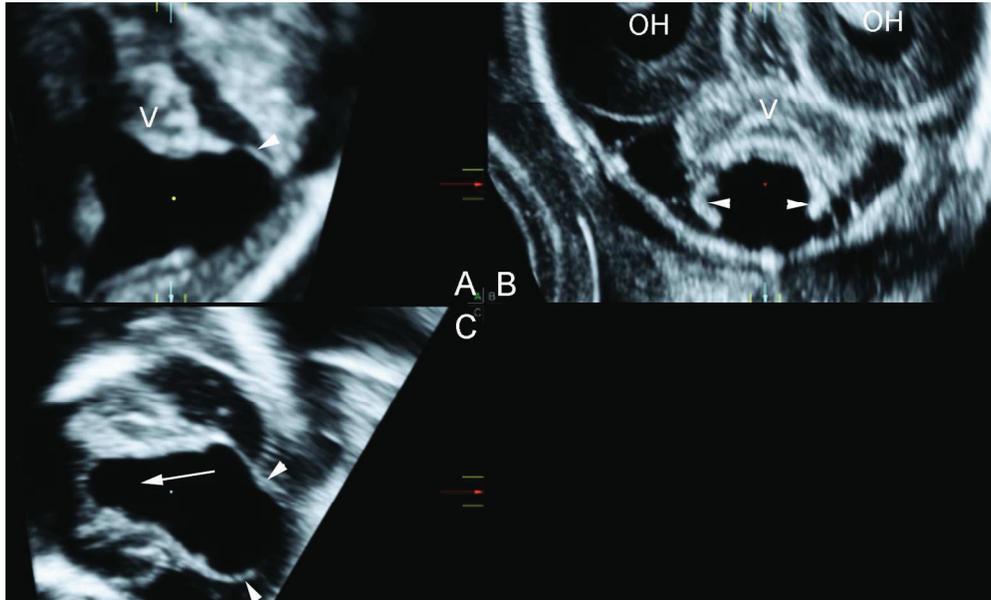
Blake's Pouch Cyst at 22 weeks of gestation. Three-dimensional ultrasound with multiplanar and volume contrast imaging. A) on the midsagittal view, the anti-clockwise rotation of the normal vermis (V) and the roof of the Blake's pouch cyst (arrowhead) are evident; B) on the corresponding coronal view, two tufts of choroid plexus (arrowhead) can be seen on the supero-lateral margins of the cyst wall, just below the vermis (V); C) on the axial plane, the classic "keyhole sign" (arrow) is seen, with non-visualization of the vermis in between the two cerebellar hemispheres. This sign leads to referral for expert opinion and final diagnosis. The lateral walls of the cyst are evident (arrowheads).
